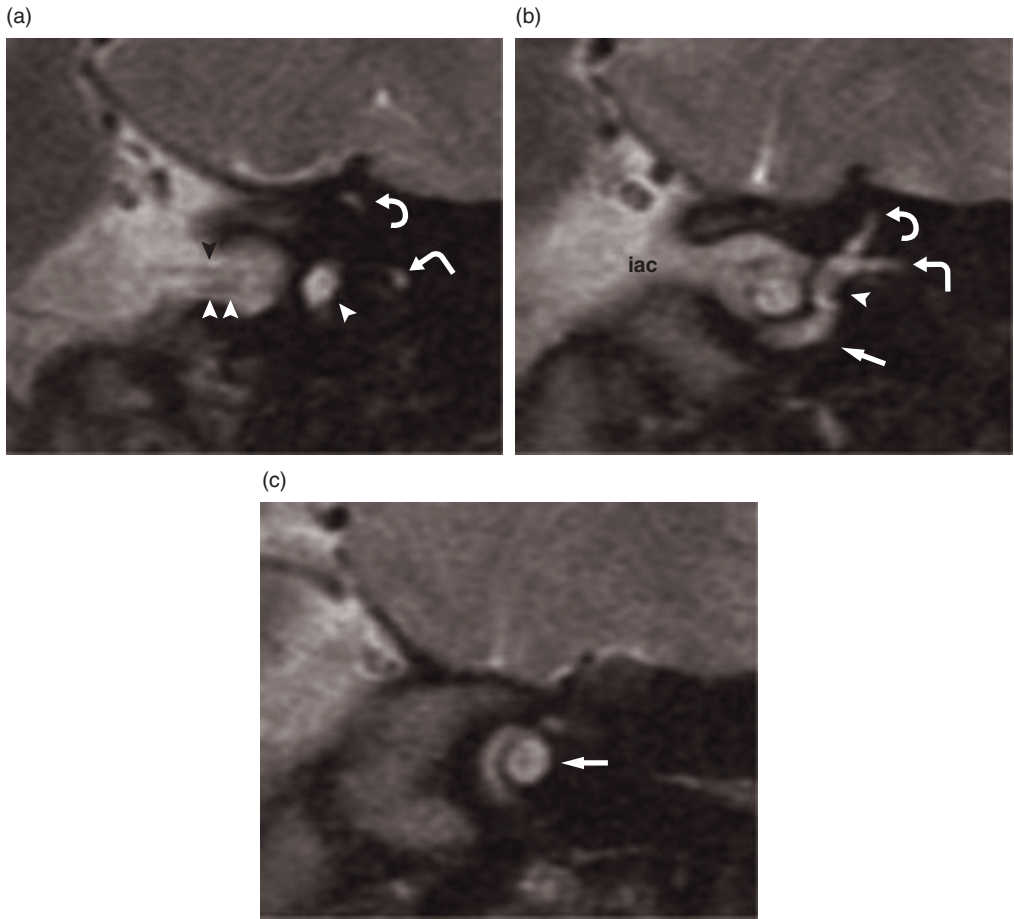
Coronal T2-weighted MR images. (a) vestibule (white arrowhead), superior semicircular canal (curved arrow), lateral semicircular canal (angled arrow), superior vestibular nerve (black arrowhead), inferior vestibular nerve (double arrowhead); (b) cochlea (straight arrow), vestibule (white arrowhead), superior semicircular canal (curved arrow), lateral semicircular canal (angled arrow), internal auditory canal (iac); (c) cochlea (arrow).
